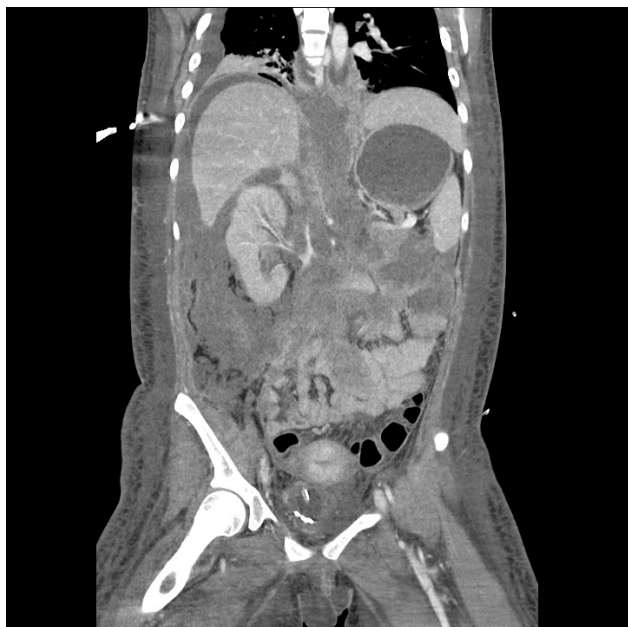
Post-operative abdominal-pelvis enhanced computed tomography. Marked progression of the pseudomyxoma peritonei in the right kidney and compression of the inferior vena cava, abdominal aorta, and branches of great vessels.
